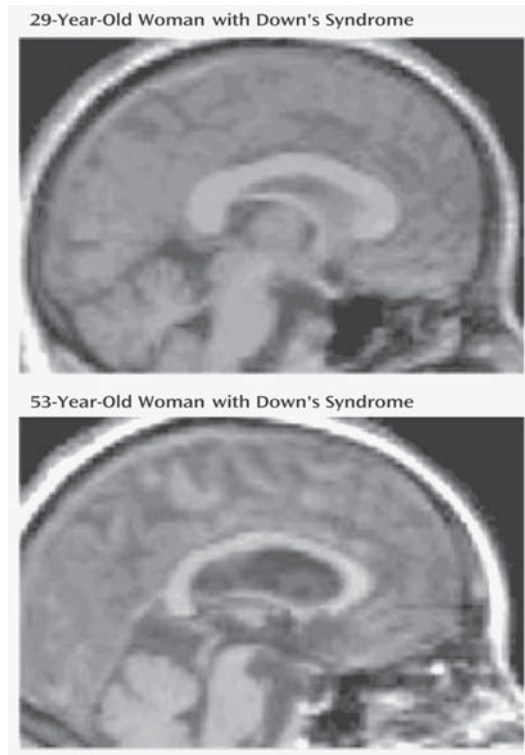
Both scans are T1-weighted images from patients with DS. Significant differences in brain morphology were found between younger and older subjects with DS not yet showing clinical features of dementia. Most notable were bilateral reductions in hippocampal volume and a reduction in corpus callosum area, which was most prominent in the posterior portion. From Teipel et al. (2003). Copyright 2003 by the American Psychiatric Association. Reprinted by permission.
